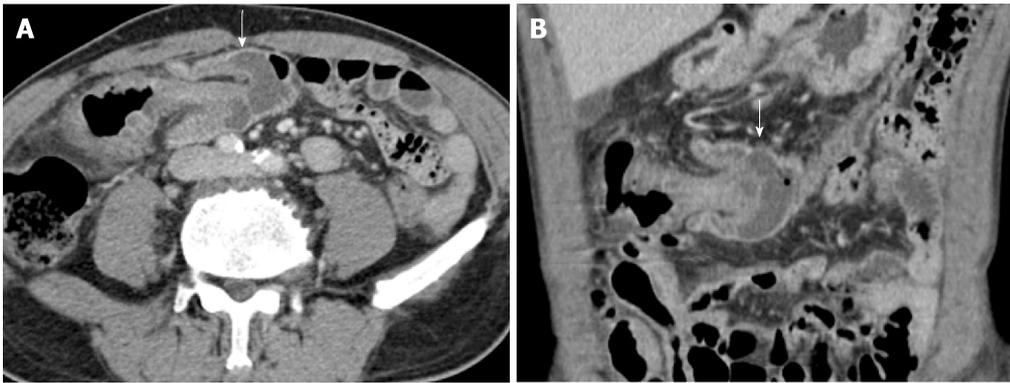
Pre-treatment abdominopelvic computed tomography. A and B: Axial and coronal reformatted images of contrast-enhanced computed tomography show a colo-colonic intussusception with subepithelial edema in mid transverse colon (white arrows). There is no evidence of visible tumor at intussusception in computed tomography.
